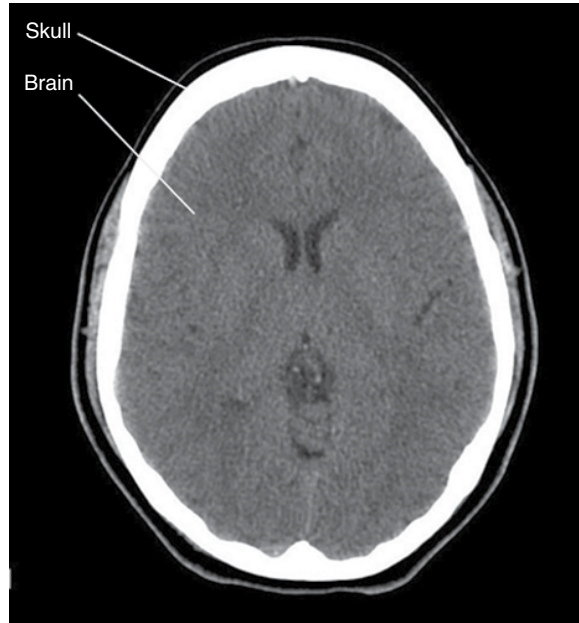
Axial (transverse) CT of skull and brain (imagine looking down at the skull and brain from the top after it had been cut open but the image produced shows the right side of the brain on the left side of the image). Note that a CT shows much less brain tissue detail than the MRI shown in Figure I.11. CT scans take much less time to obtain than MRI scans and are also less expensive.
